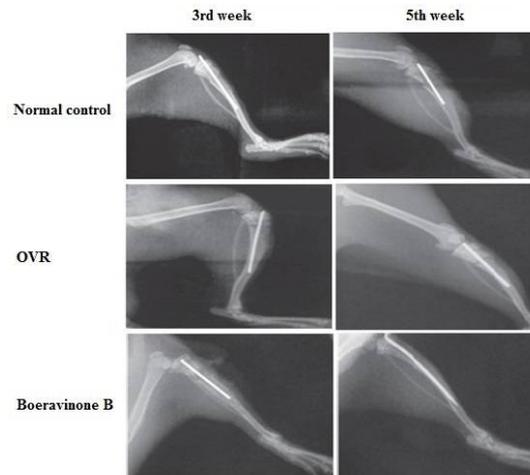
Effect of boeravinone B on remodeling of tibia as revealed by x-ray analysis
